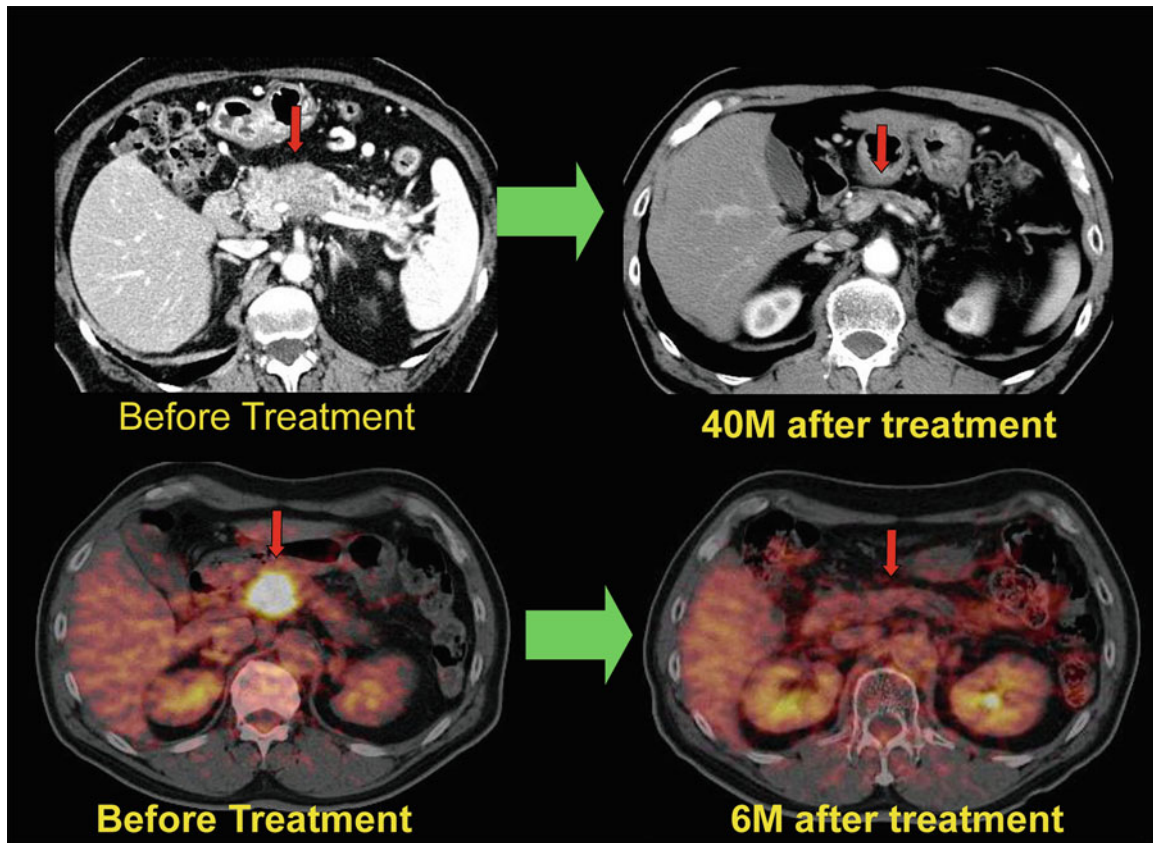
This patient was a 66-year-old man with pancreatic cancer. He received a total dose of 50.4 GyE via carbon ion beams in 12 fractions. Both the CT at 40 months and the FDG accumulation at 6 months post treatment demonstrated the disappearance of the pancreatic tumor
